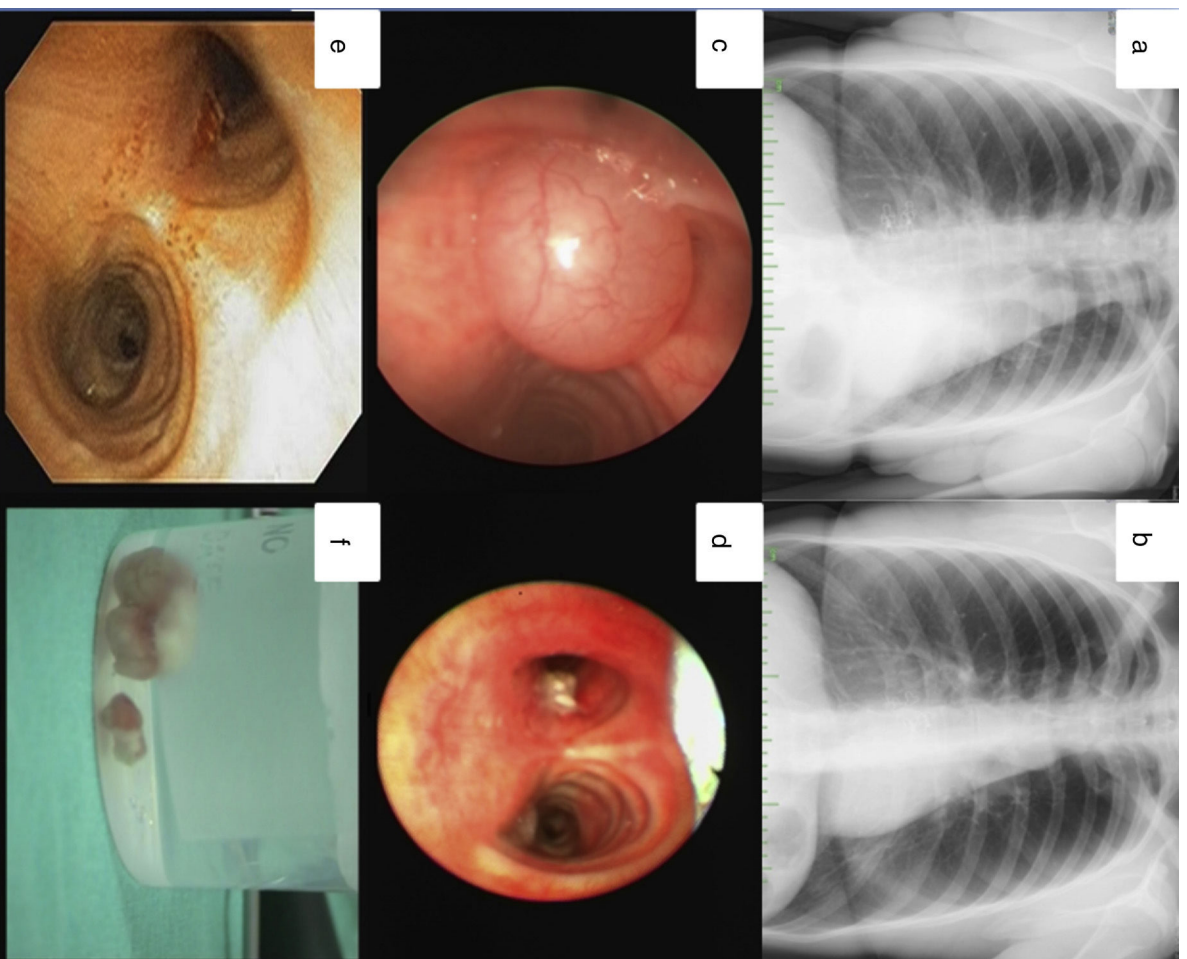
Chest X-ray before (a) and after intervention (b), showing disappearance of left lower lobe atelectasis. On bronchoscopy (c), a vegetating, pedunculated lesion covered with a normal bronchial epithelium was obstructing the left main bronchus. Bronchoscopic view after resection (d) and after one month (e). Resected material (f).
